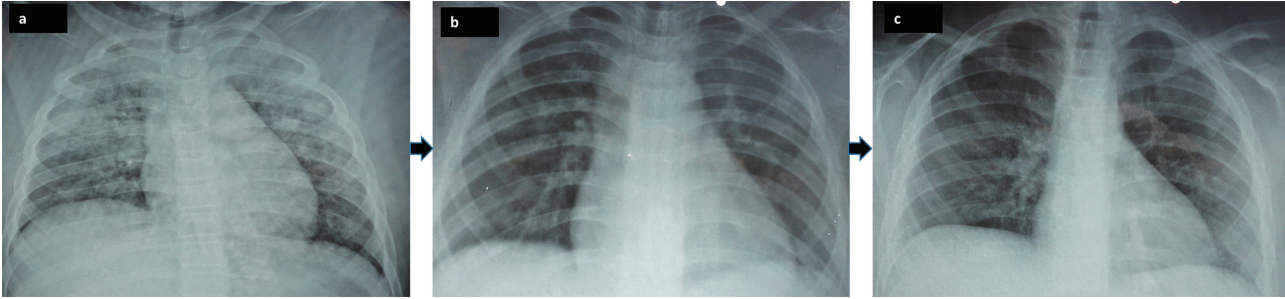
The evolution of chest X-rays in the child with HCPS during hospitalization in the intensive care unit, in the Pantanal region of Mato Grosso State, 2016. A) Admission – the chest X-ray revealed the presence of a diffuse bilateral pulmonary infiltrate – March 4, 2016; B) Six days after the onset of illness – March 10, 2016; C) Eleven days after the onset of illness – March 15, 2016.
